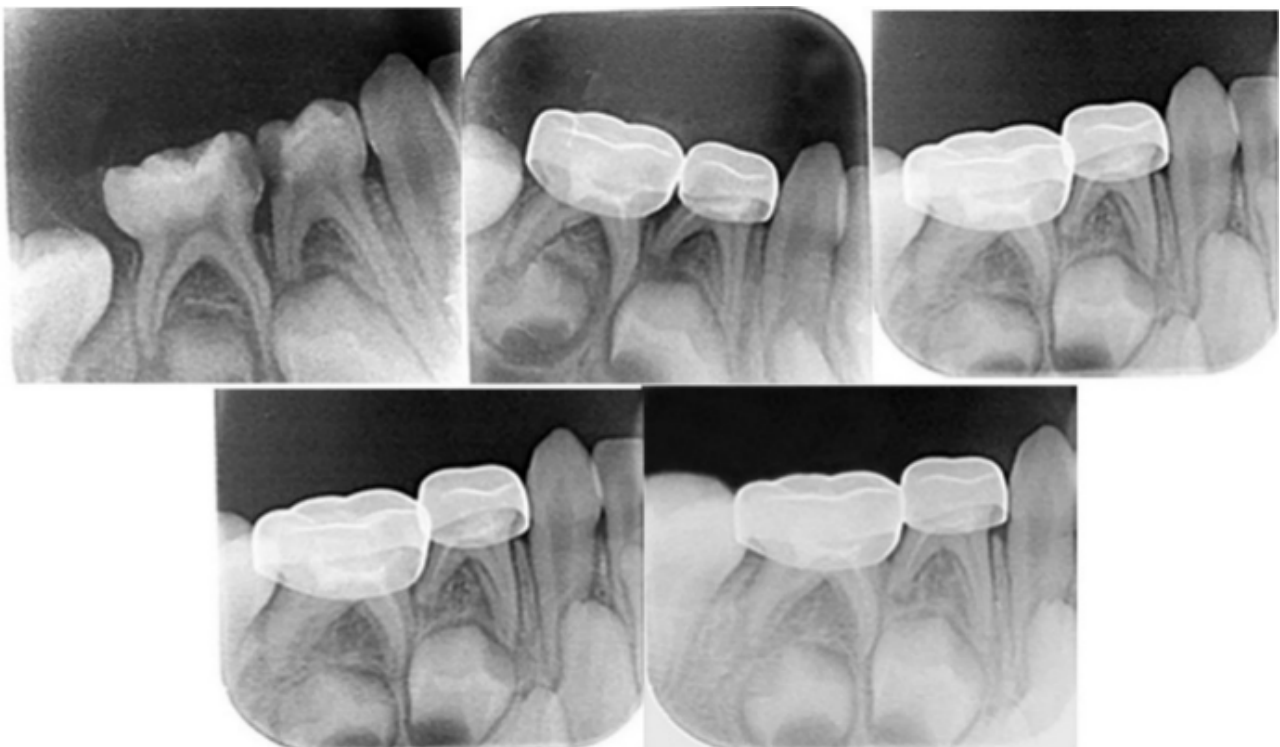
A: pre-operative radiograph showing proximal caries between lower left D and E, B: base line image immediately after restoration with Acemannan and (C-D): follow up periods at 3, 9 and 12 months post restoration respectively.
